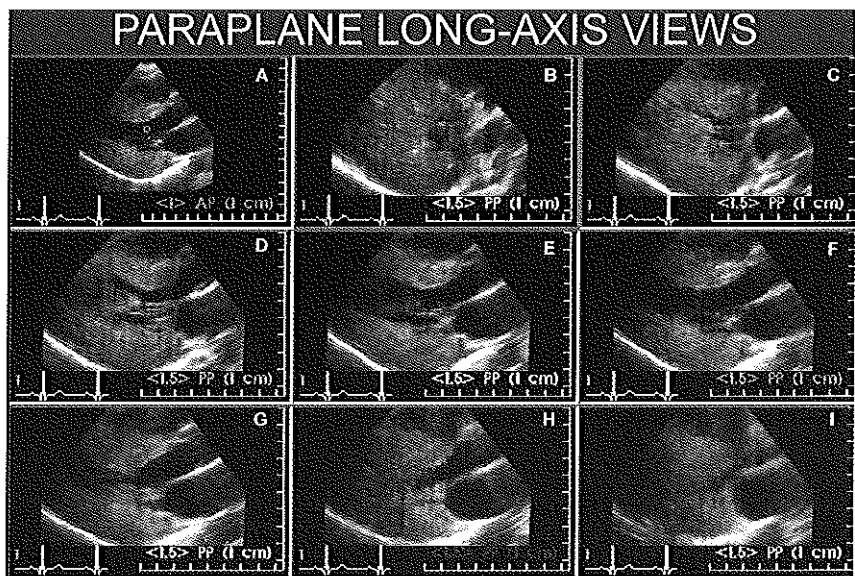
The same patient as in figure 5. The left ventricle is now sliced in planes parallel to the long axis view from interventricular septum to the lateral wall. Panel E corresponds to the standard parasternal long-axis view.
